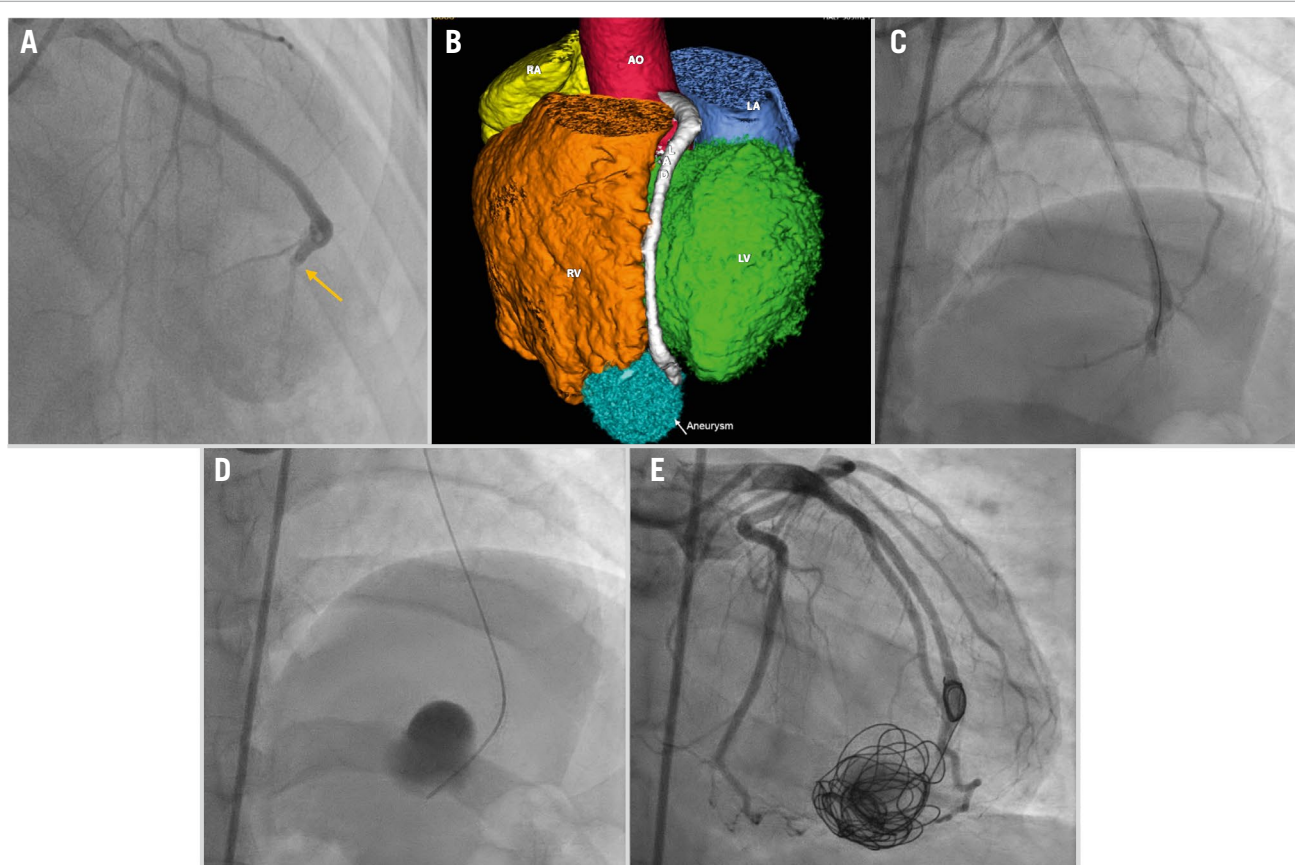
Management of giant coronary aneurysm. A) The coronary angiogram showed a jet of contrast into a giant coronary aneurysm from the left anterior descending artery (LAD). B) Cardiac computed tomography revealed the presence of a large aneurysm from the LAD burrowed in the apical myocardium of the right ventricle. C) The narrow mouth of the aneurysm was crossed with a balance middle weight (BMW) 0.014" guidewire (Abbott). D) The Progreat microcatheter (Terumo) was advanced into the aneurysm over a BMW 0.014" guidewire. E) Four Concerto detachable coils (Medtronic) were deployed: 3 inside the aneurysm and 1 at the end of the distal LAD. AO: aorta; LA: left atrium; LV: left ventricle; RA: right atrium; RV: right ventricle
